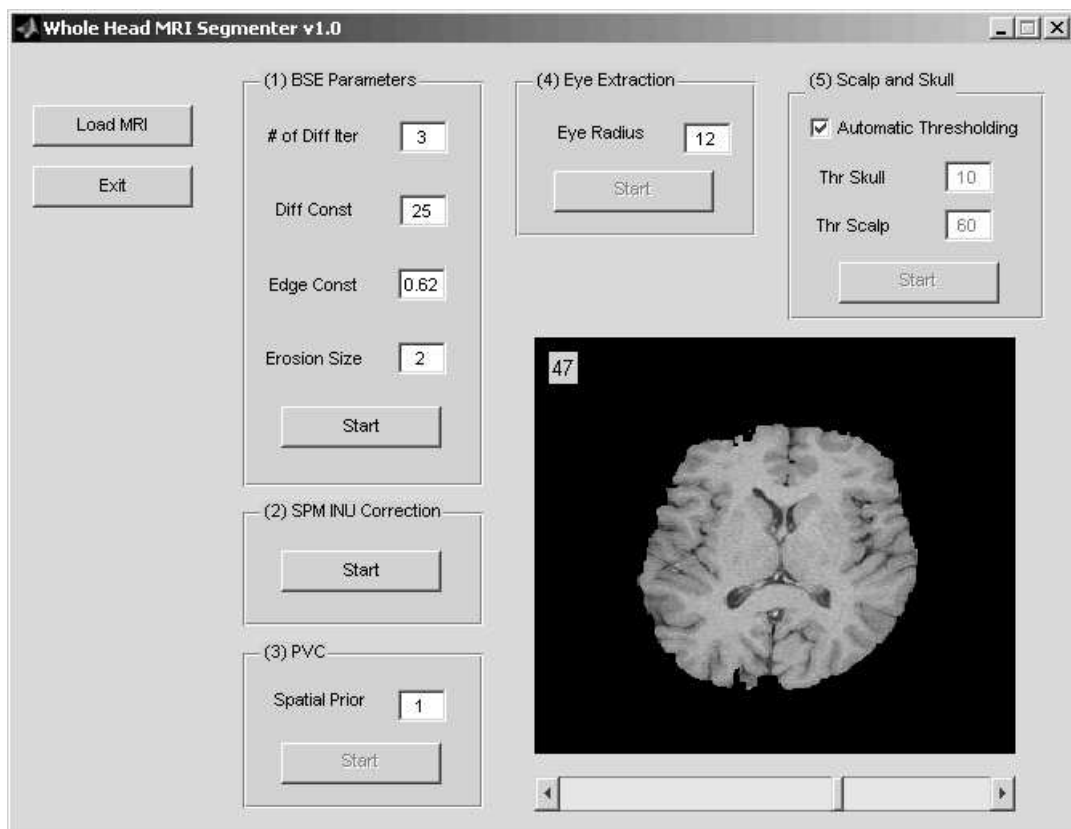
Whole head MRI segmentation software Graphical User Interface.
